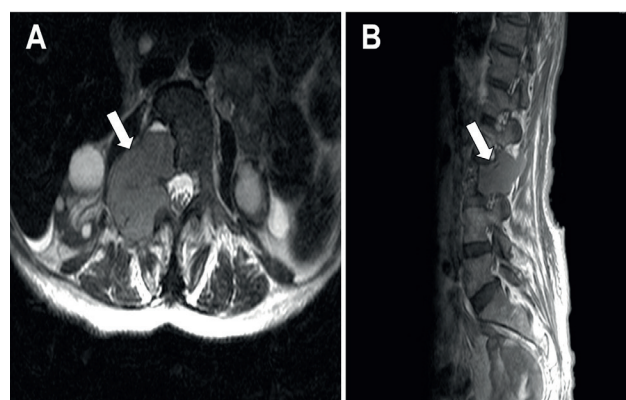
MRI scan of lumbar spine demonstrates a metastatic lesion (arrows) in the right lateral region of L3 vertebral corpus (A: axial and B: sagittal sections).
